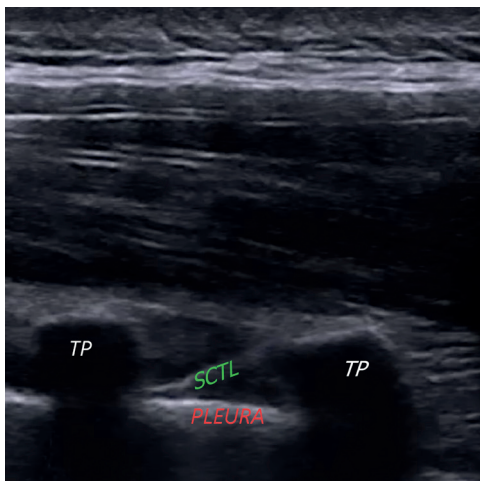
Ultrasonographic anatomy for thoracic paravertebral block
